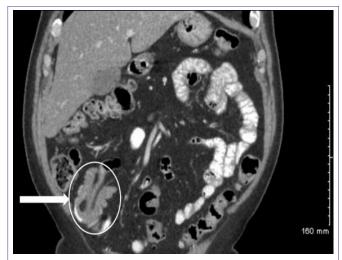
A CT scan of the abdomen showing entercenteric intussusception of the distal small bowel.
